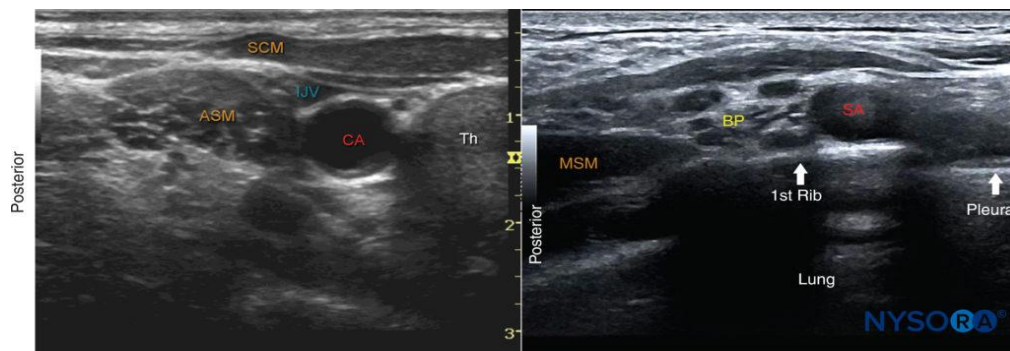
(A) Ultrasound image just below the level of the cricoid cartilage and medial to the sternocleidomastoid muscle (SCM). ASM, anterior scalene muscle; CA, carotid artery; IJV, internal jugular vein; SCM, sternocleidomastoid muscle; Th, thyroid gland. (B) View of the brachial plexus (BP) at the supraclavicular fossa. When identification of the brachial plexus at the interscalene level proves difficult, the transducer is positioned at the supraclavicular fossa to identify the BP superficial and posterior to the subclavian artery (SA). The transducer is then slowly moved cephalad while continuously visualizing the brachial plexus until the desired level is reached (Brown, 2010).
